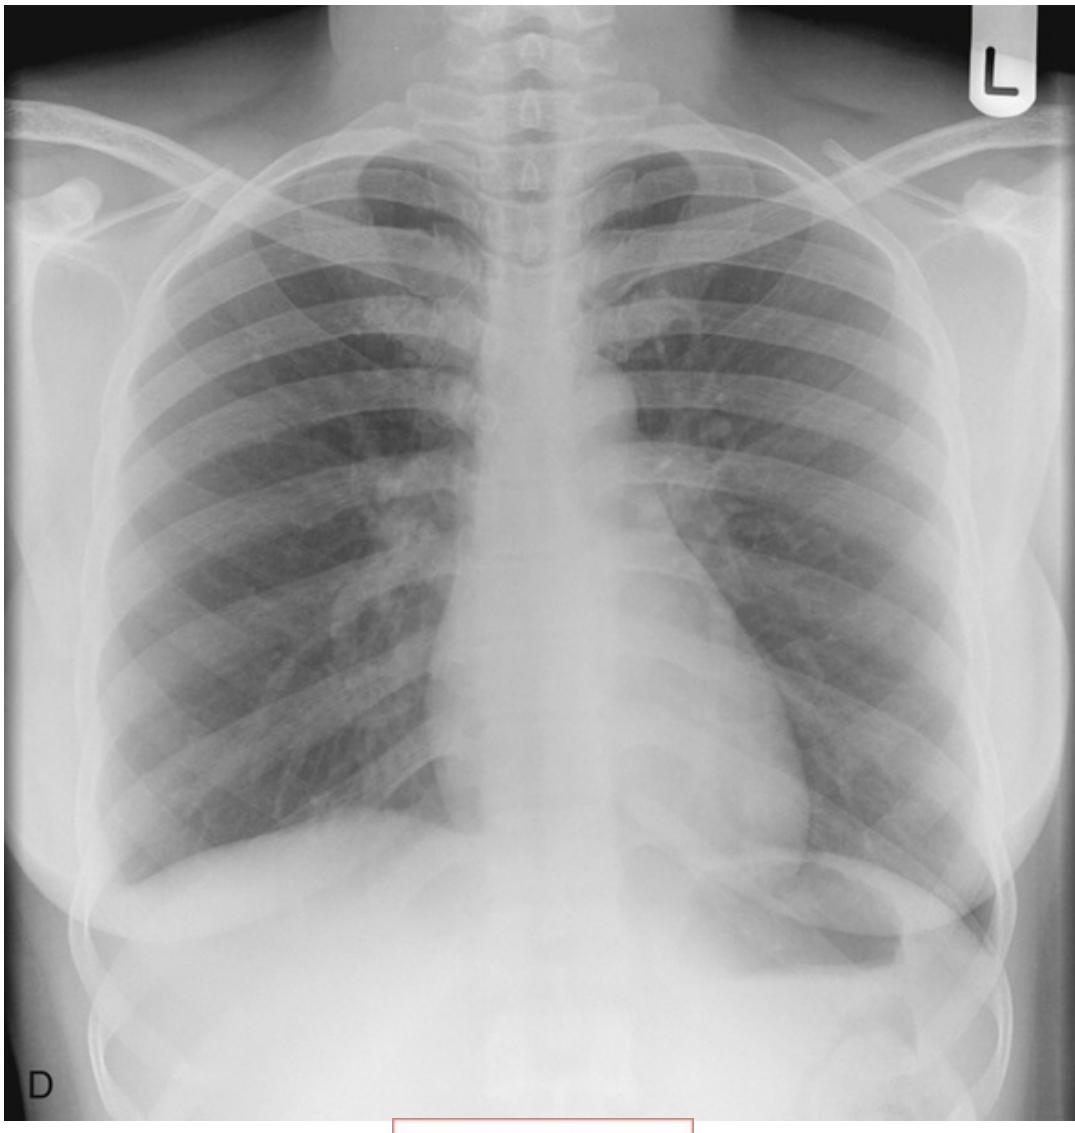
The next four x-rays are examples of how the technical quality of a film can affect its appearance and potentially lead to misinterpretation. (A) is an anterior-posterior (AP) film which shows how the scapulae are projected over the thorax and the heart appears large. (B) is a standard posterior-anterior (PA) projection showing how the scapulae no longer overlie the thorax and the heart size now appears normal. (C) is taken with a poor inspiration. Note how poor inspiration makes the lung bases look whiter, and the heart size appears larger. (D) is taken with a good inspiration. Note how poor inspiration makes the lung bases look whiter, and the heart size appears larger.
